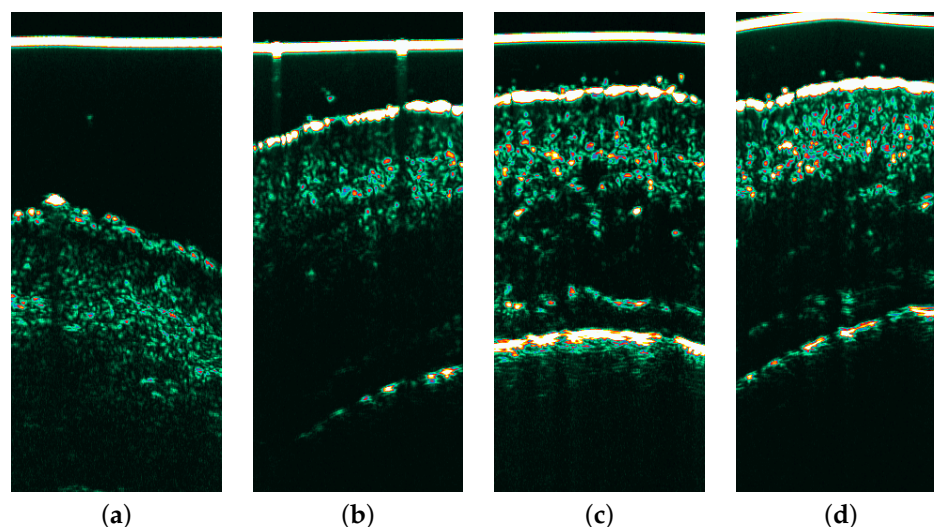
Ultrasound imaging of the AK1 site: (a) before therapy, (b) follow-up week 4, (c) follow-up week 8, (d) follow-up week 12. A reduction in the SLEB layer is visible within the 4, 8, 12 week follow-ups and the occurrence of hyperechogenic pixels throughout the patients' visits.
